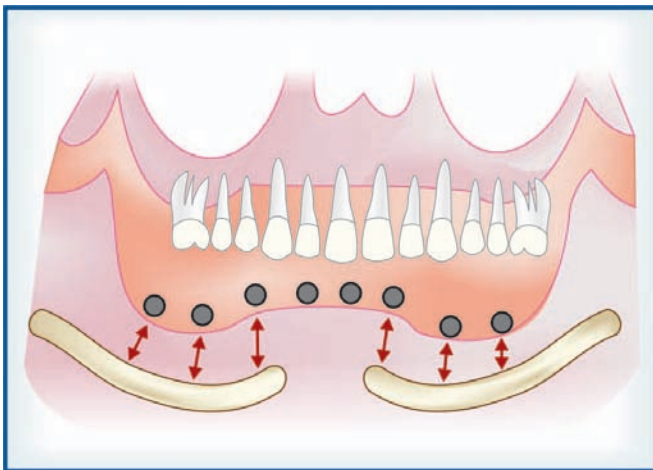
Radiographic view
